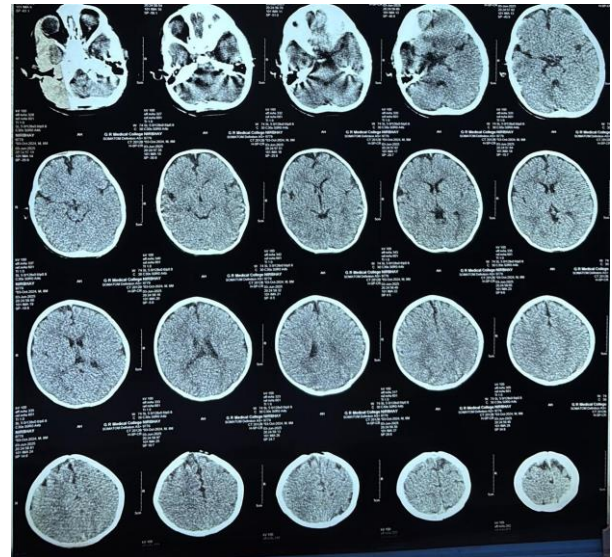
Non-contrast CT head at one-month follow-up, showing complete resolution of the extradural hematoma.
